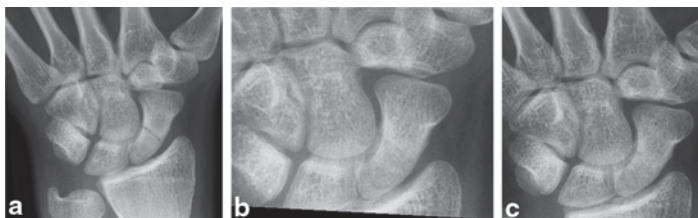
AP radiographs obtained at 7 a, 11 b, and 15 c weeks after the injury demonstrate progressive healing of the fracture. (Published with kind permission of ©Megan Tomaino and Thomas B. Hughes, 2015. All rights reserved)
